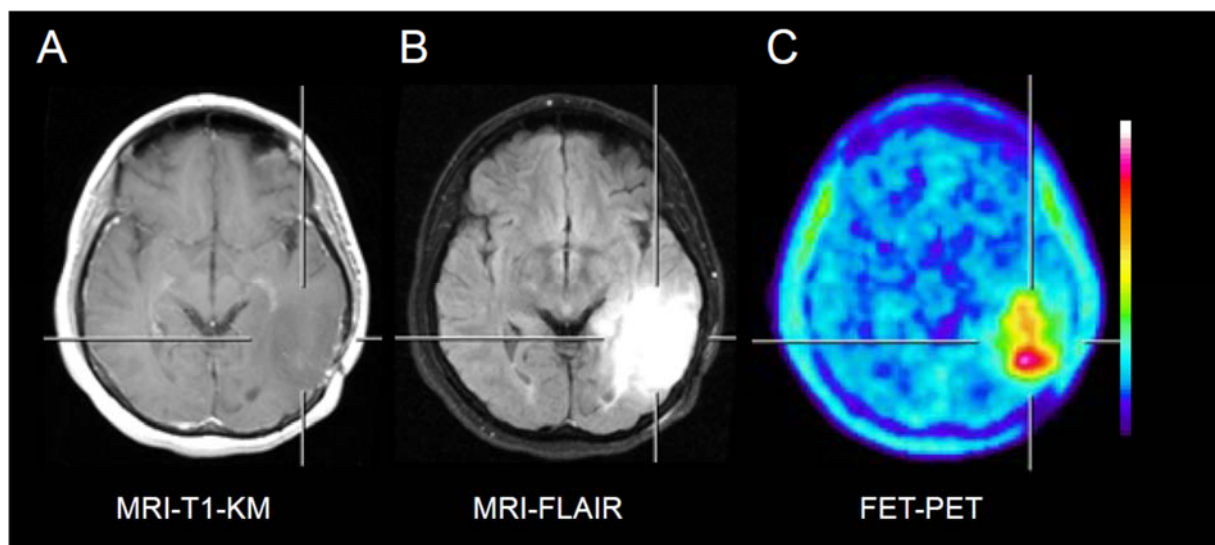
Patient with suspicion of tumor recurrence of an anaplastic astrocytoma WHO Grade III after resection and radiochemotherapy. Contrast-enhanced T1-weighted MRI (A) shows no clear contrast enhancement and the FLAIR (B) large area of signal abnormality which is difficult to differentiate from treatment related changes. In contrast, FET-PET (C) clearly depicts recurrent tumor tissue. Institute of Neuroscience and Medicine, Forschungszentrum Jülich, Germany.
